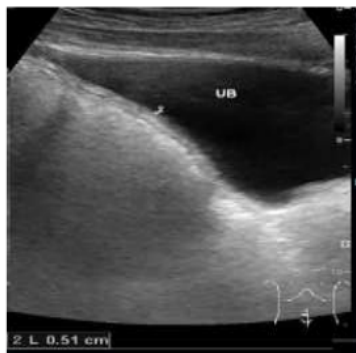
Cystitis in ultrasound, the thickness of the bladder wall >3.0mm
